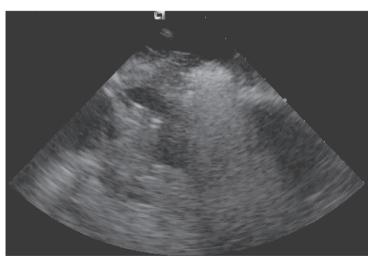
Image of the SRA (with ethanol) visualized by intracardiac echocardiography. Note the marked shadowing effect.
